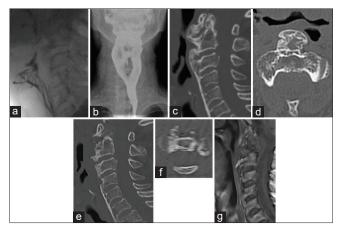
Diagnostic studies of case 4. (a and b) Barium swallow study in lateral (a) and antero-posterior (b) views: Defect of the esophageal opacization at level of the osteophyte. (c and d) Preoperative cervical CT scan, sagittal (c) and axial C1–C2 (d) views: Anterior osteophyte extending from C1 to C3-C4 level; the calcified anterior longitudinal ligament is visible. (e-g) Postoperative studies: Cervical CT scan, sagittal (e) and axial C1–C2 (f) sections; magnetic resonance, sagittal T1-W sequence (g): Good resection of the osteophyte and normal esophageal lumen
